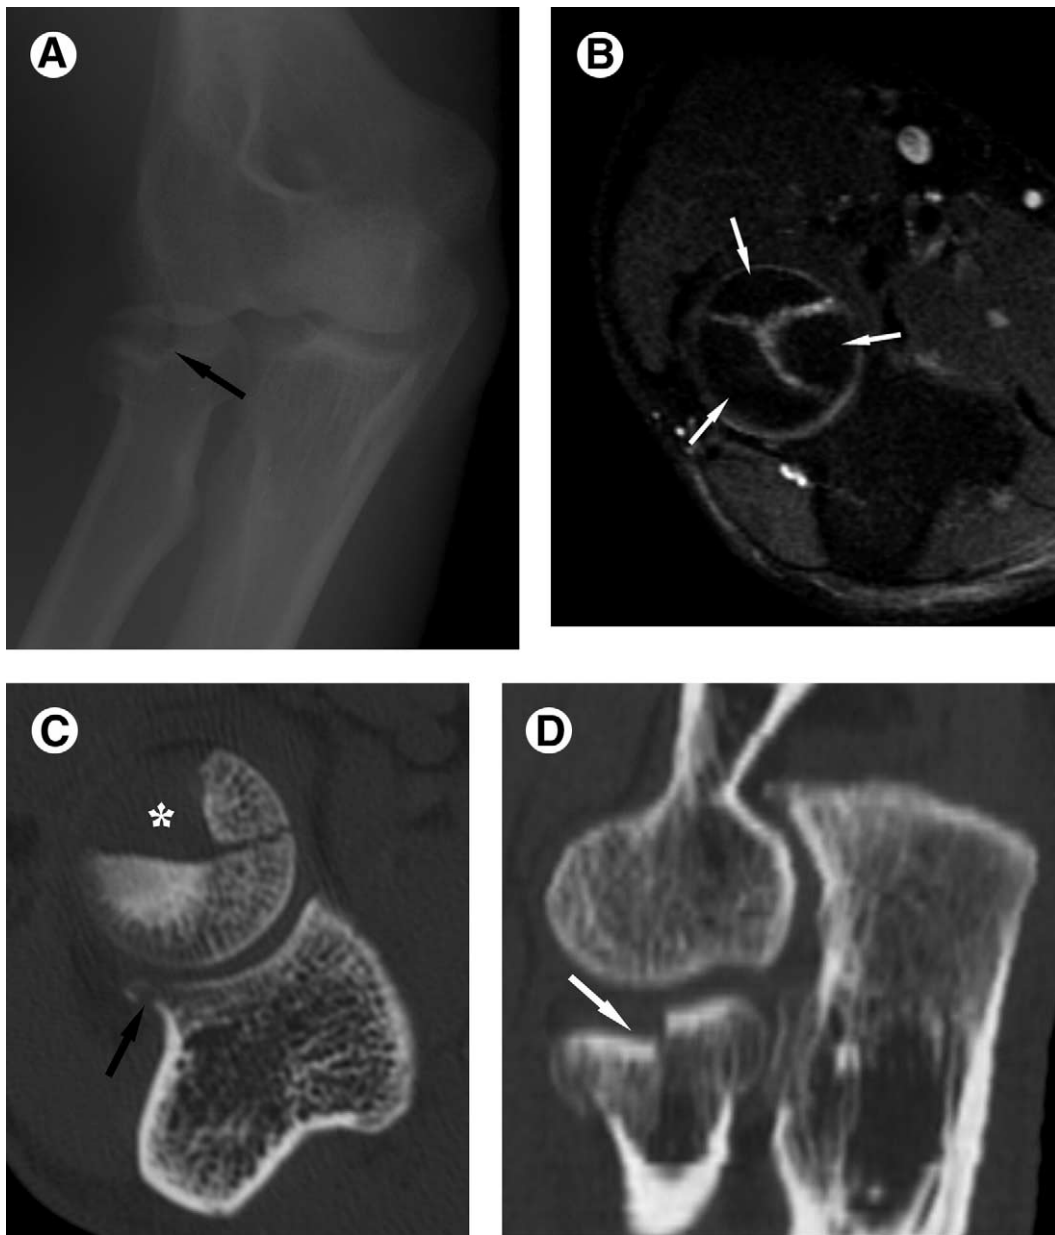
Comminuted fracture. (A) Lateral oblique view demonstrates intraarticular comminuted radial head fracture (arrow) with depressed anterior component. (B) Axial T2-weighted MR image with fat-saturation well shows comminuted components (arrows). Axial (C) and sagittal (D) reformatted CT images allow accurate evaluation of degree of comminution, displacement, and intraarticular step-off (asterisk, white arrow) of fracture fragments. Unsuspected minimally displaced fracture of proximal ulna is also well demonstrated (C, black arrow).
